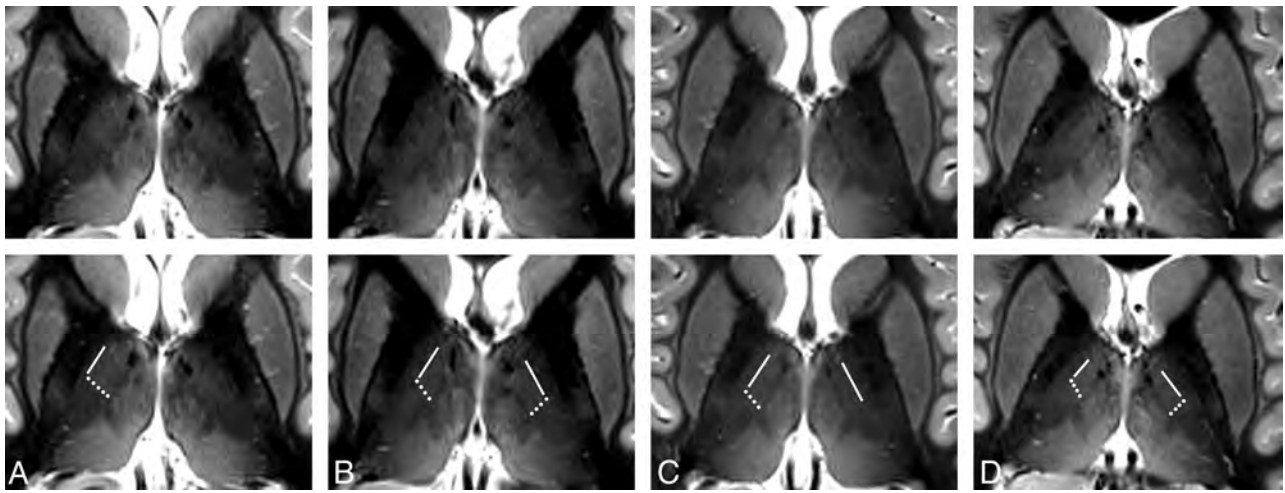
Axial MR images of different subjects. Axial sections through the thalamus in a plane approximately 10 mm dorsal to the ACPC plane of 4 different subjects (A–D) acquired with an IR-TSE sequence (TI = 500 ms and $0.7^2 \times 2 \text{ mm}^3$ resolution). In the bottom row, which is identical to the top row, lines mark the border between the anatomic subfields D.o.i and D.o.e and dotted lines show the border between the subfields D.o.i and Z.im.i. In the left hemispheres in A and C, diffuse-appearing boundaries are not marked. At this coarser in-plane resolution, the Lam appears more blurred than in Figs 1 and 2. Some images show blood flow artifacts in the medial thalamus (see also Fig 5).
